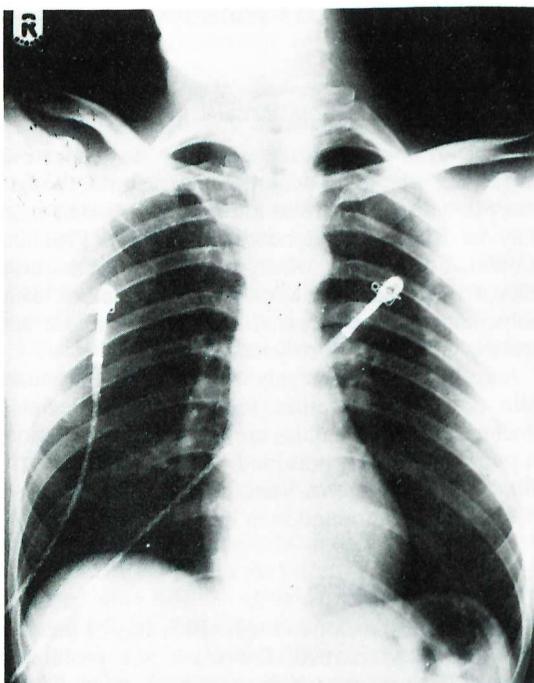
Chest X-ray on admission (a) and 15 days later (b) showing patchy infiltration in both lung fields
